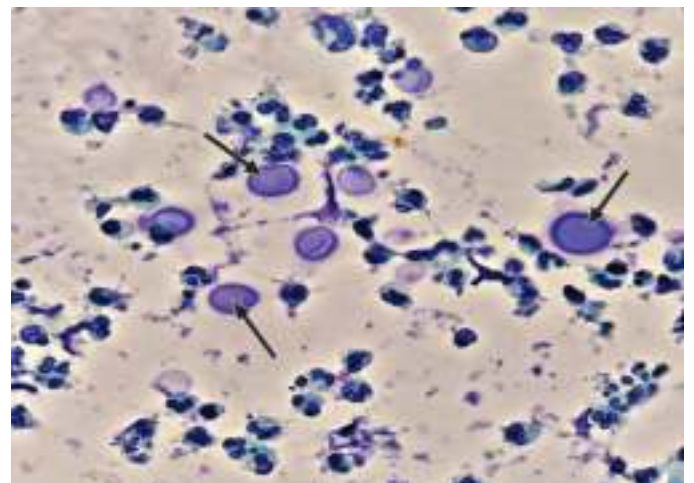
Endobronchial ultrasound (EBUS) bronchoscopy demonstrates *Cryptococcus neoformans* (arrows) (400X).
